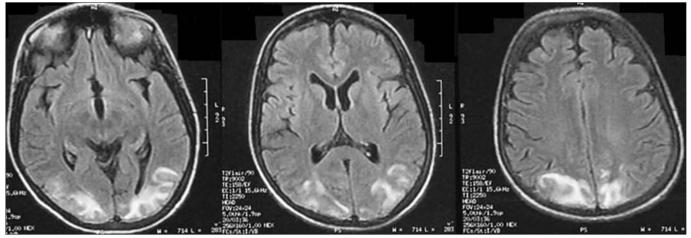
Axial fluid-attenuated inversion recovery (FLAIR) MR images show symmetrically located, bilateral hyperintense lesions in the parietooccipital regions affecting the cortex and subcortical white matter.
